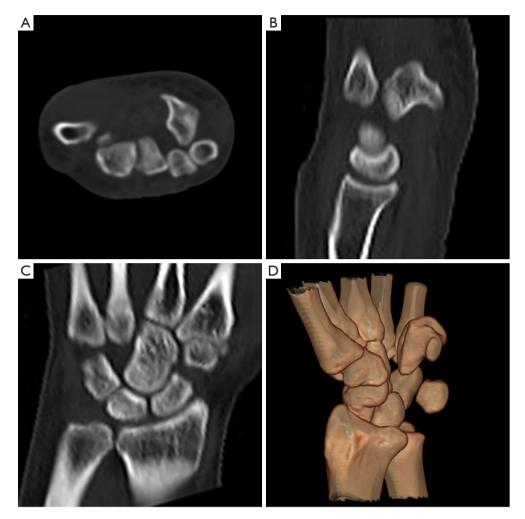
CT cross sections (A) showed forward rotation and displacement of the distal end of the hamate bone and compression of the walking area of the ulnar nerve. CT sagittal plane (B) showed the rotation and displacement of the distal end of the hamate bone to the volar side and the base of the 4th and 5th metacarpal bones to the proximal and dorsal sides; CT coronal plane (C) showed a void between the capitate bone and the triangular bone, suggesting the sign of loss of hamate bone, and the base of the 4th and 5th metacarpal bones had proximal displacement; CT three-dimensional reconstruction (D) showed that the hamate bone moved forward on the volar side of the wrist bone, the distal end of the hamate bone rotated to the volar side, and the base of the 4th and 5th metacarpal bones moved proximally.
